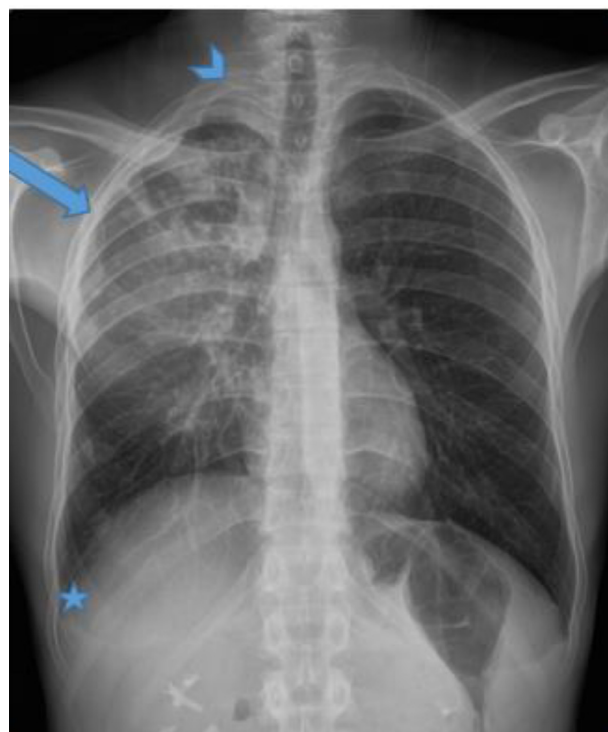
Chest X-Ray: Soft tissue thickness of the right hémithorax (Arrow). Right costophrenic angle blunt without significant fluid (Asteric). Fibrosis in the right apexes (Arrowhead).
